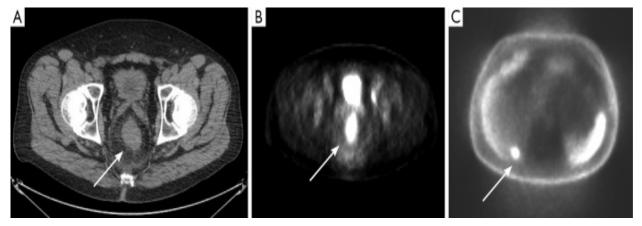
PET / CT of rectal tumor with liver metastasis (arrows).
